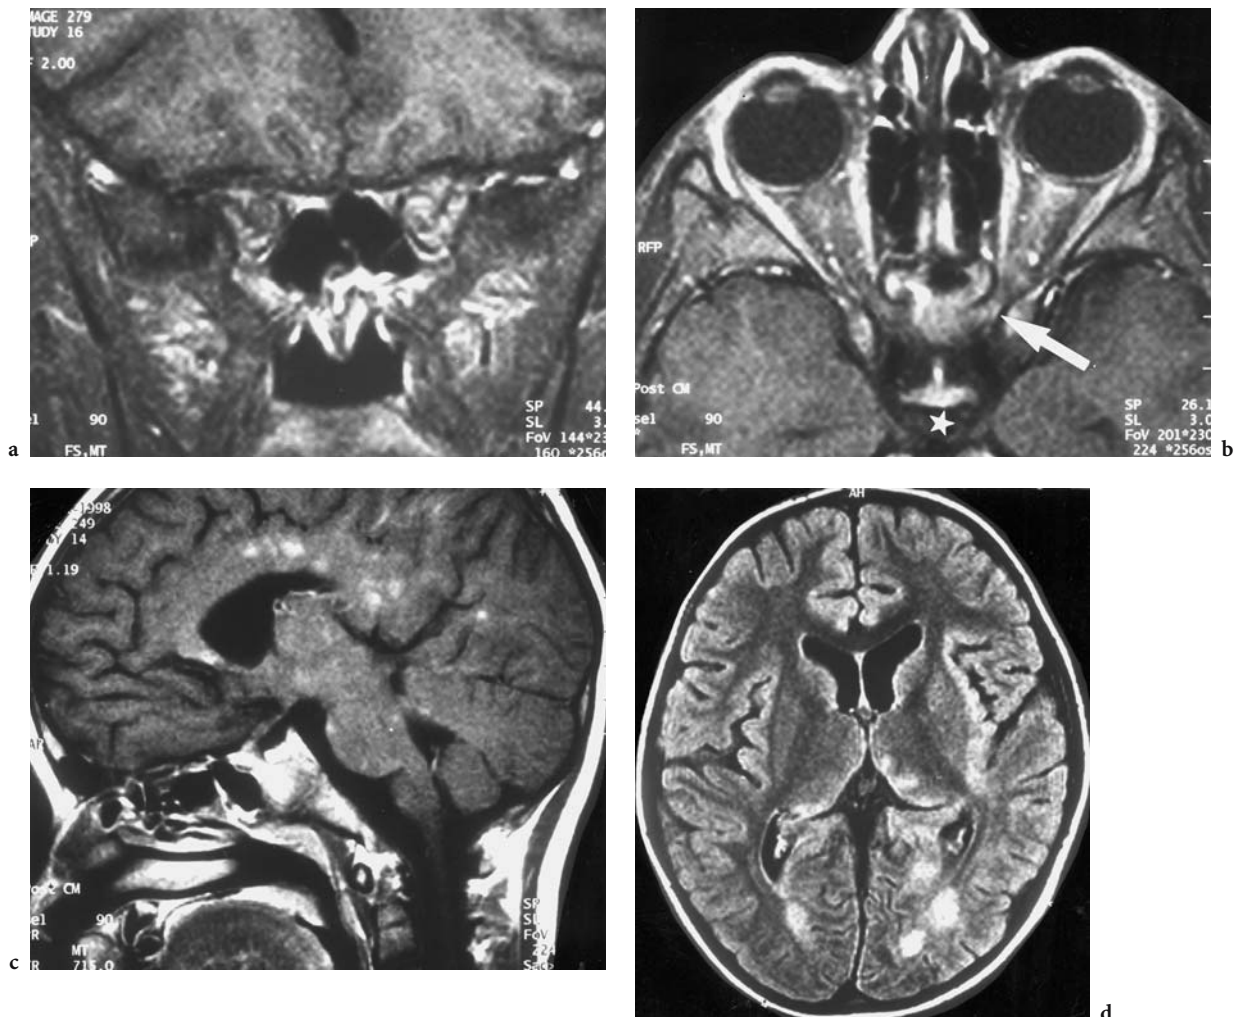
A 3-year-old boy with acute (not longer than 12 h) bilateral loss of vision (0.1) and acute, diffuse, disseminated pain in all parts of the body. Diagnosis: ADEM (acute disseminated encephalomyelitis). MRI: a Coronal T1-weighted (FS plus MT) native sequence demonstrating spontaneous signal enhancement of the left optic nerve in the optic canal. b Axial, T1-weighted, contrast-enhanced (FS) view, where the BBB disruption is accentuated after i.v. gadolinium (*white arrow*), including the chiasm (*white star*). c Left paramedian sagittal, T1-weighted, contrast-enhanced (plus MT) view, showing not only the high signal of the intracranial optic nerve, but also BBB disruption of multiple foci in the white matter of the cingulate gyrus, parietal and occipital lobe, and brainstem. d Axial T2-weighted FLAIR image where additional inflammatory lesions are seen in both occipital lobes, in the area of the left optic radiation, and in both thalami. Clinical tests failed to confirm the differential diagnosis of multiple sclerosis (MS); however, the patient showed complete clinical recovery with increasing vision (r: 0.3, l: 0.2) after steroid therapy
